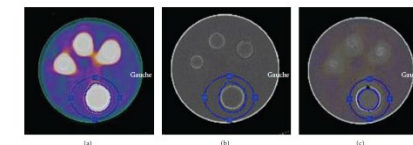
Definition of VOIs used for quantitative analysis of SPECT and SPECT/CT analysis (a, b); VOI defined on SPECT hot spot alone.
